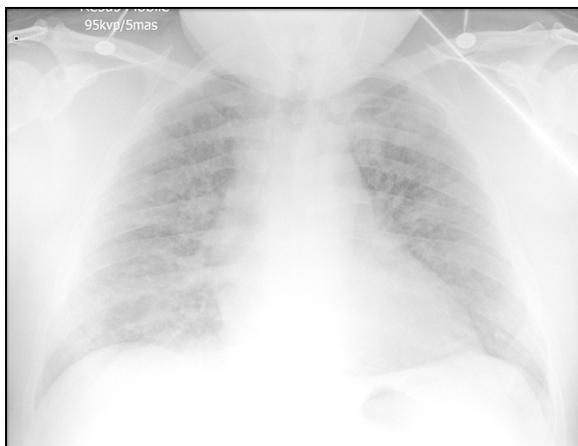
Chest X-ray taken on admission of the patient which does not show any sign of ARDS
